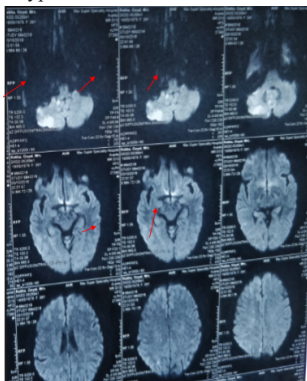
MRI head showing acute infarct in right cerebellum and right subcortical fronto-parietal region
